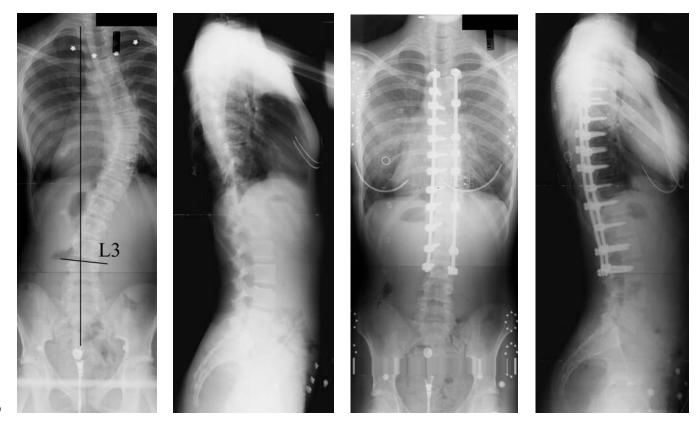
Preoperative posteroanterior (PA) and lateral radiographs of a 15-year-old girl demonstrate a 51-degree thoracic and 24-degree thoracolumbar curve (Lenke type 1AR deformity). (A,B) The patient underwent posterior spinal instrumentation and fusion with segmental
